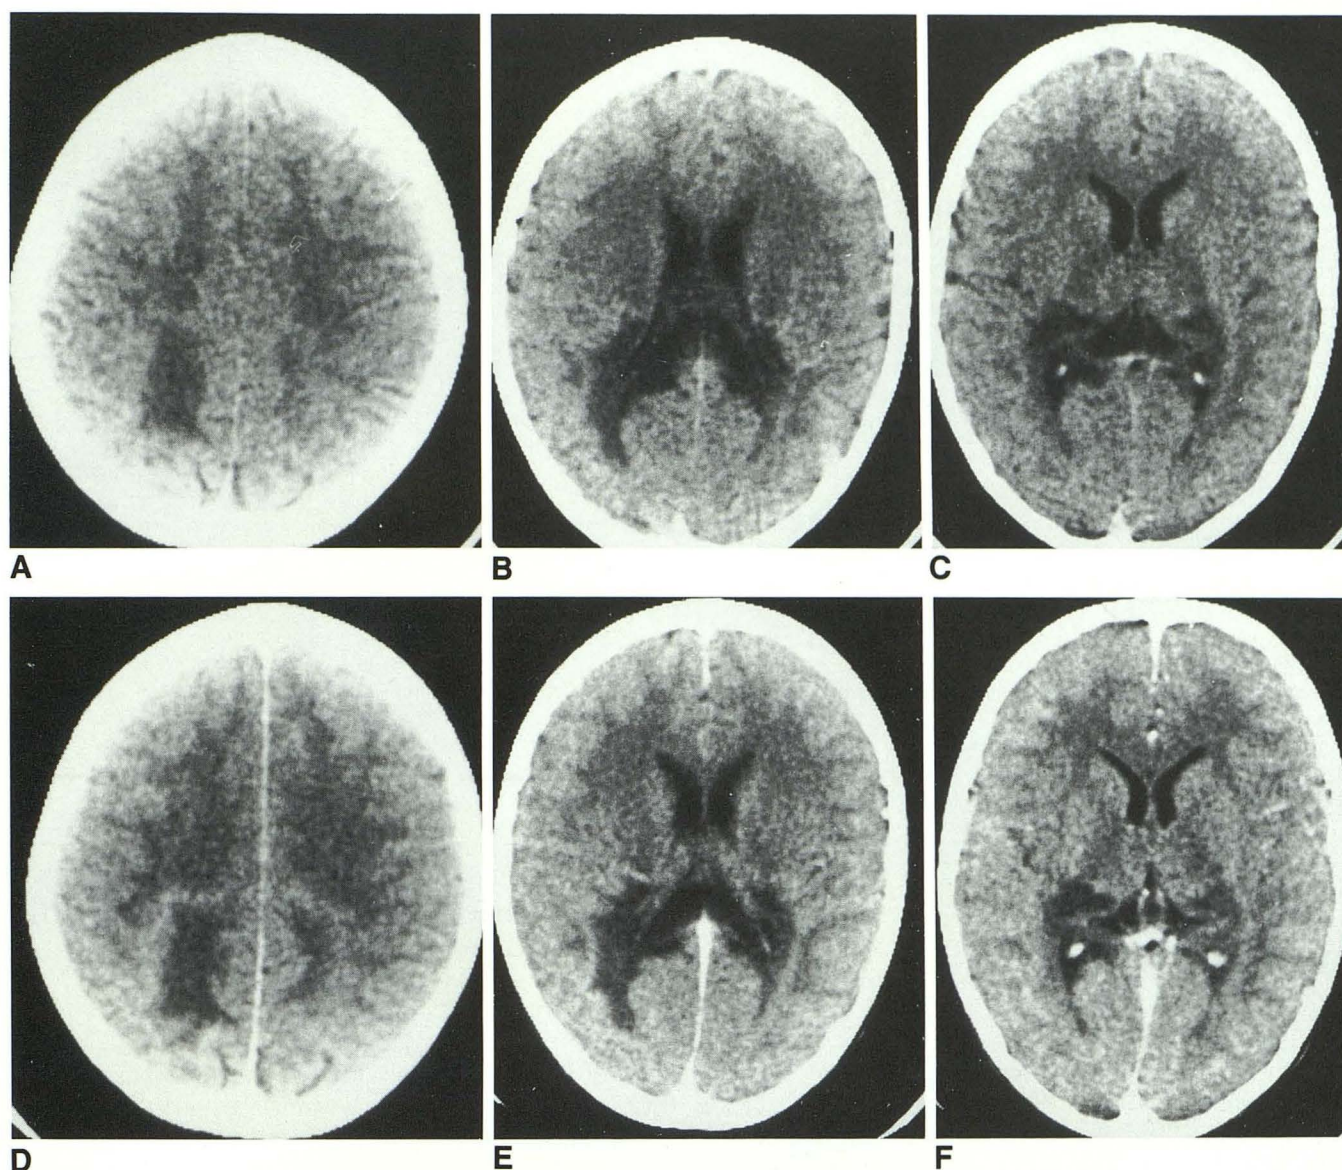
Adrenoleukodystrophy; cranial CT: before (A-C) and after (D-F) intravenous contrast administration. The lesion shows the typical three zones, with enhancement of the intermediate high-density zone, most evident in D and E. The disease involves the peritrigonal and medial parietal white matter, the splenium of the corpus callosum, the lateral geniculate bodies, and posterior parts of the thalami.
